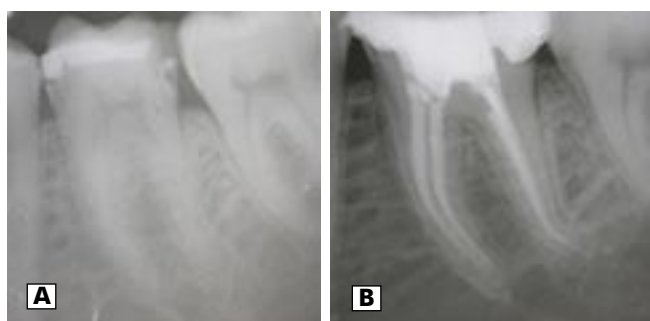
Calcified chamber and canals. (A) Pre-op radiograph helps prevent iatrogenic errors. (B) Post obturation of same case.
